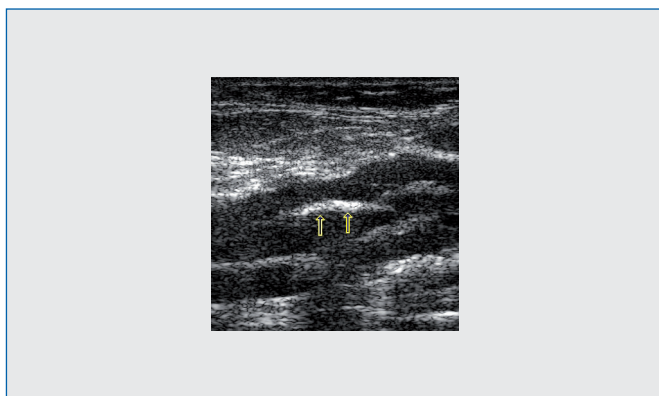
Visualization with B-mode ultrasonography of post-thrombotic endoluminal fibrous formations.
